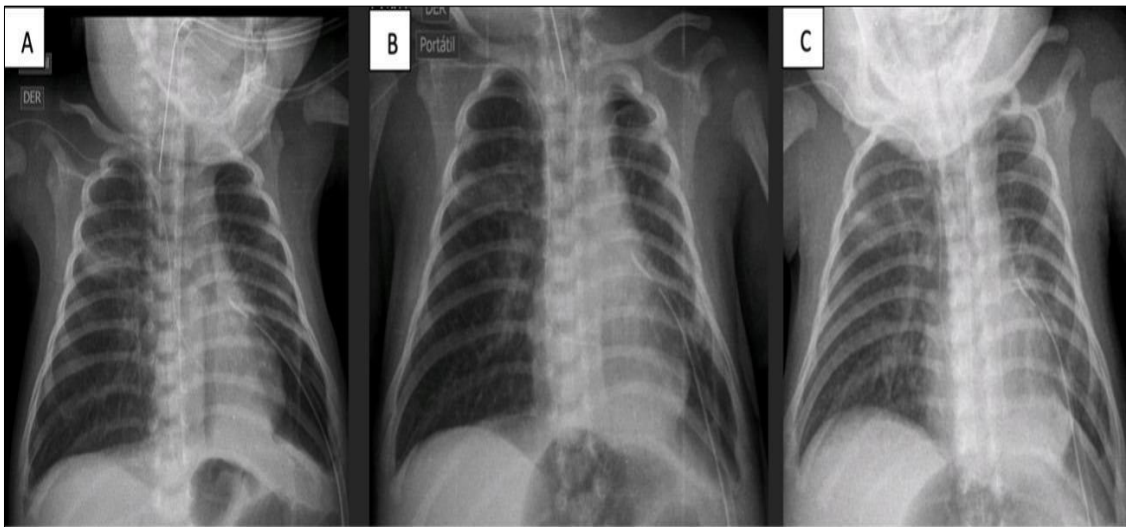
A) Chest x-ray before pleurodesis. B) Chest x-ray 24hrs post-pleurodesis. C) Chest x-ray 48hrs post-pleurodesis.
